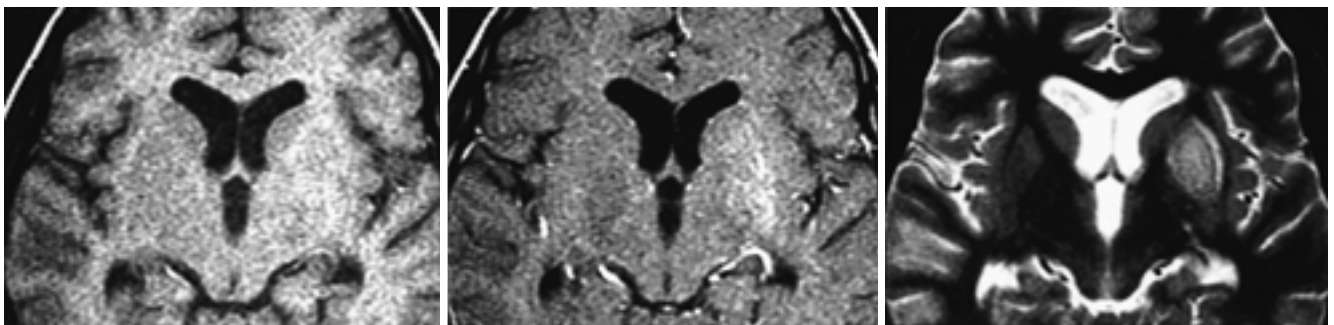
An 11-year-old man with neuropsychiatric lupus. T1-weighted axial image (A) reveals slightly increased signal intensity in left basal ganglia. Gd-enhanced T1-weighted axial image (B) reveals unilateral enhancement in left basal ganglia. In T2-weighted axial image (C) the diffuse high signal intensity is seen in left basal ganglia.
